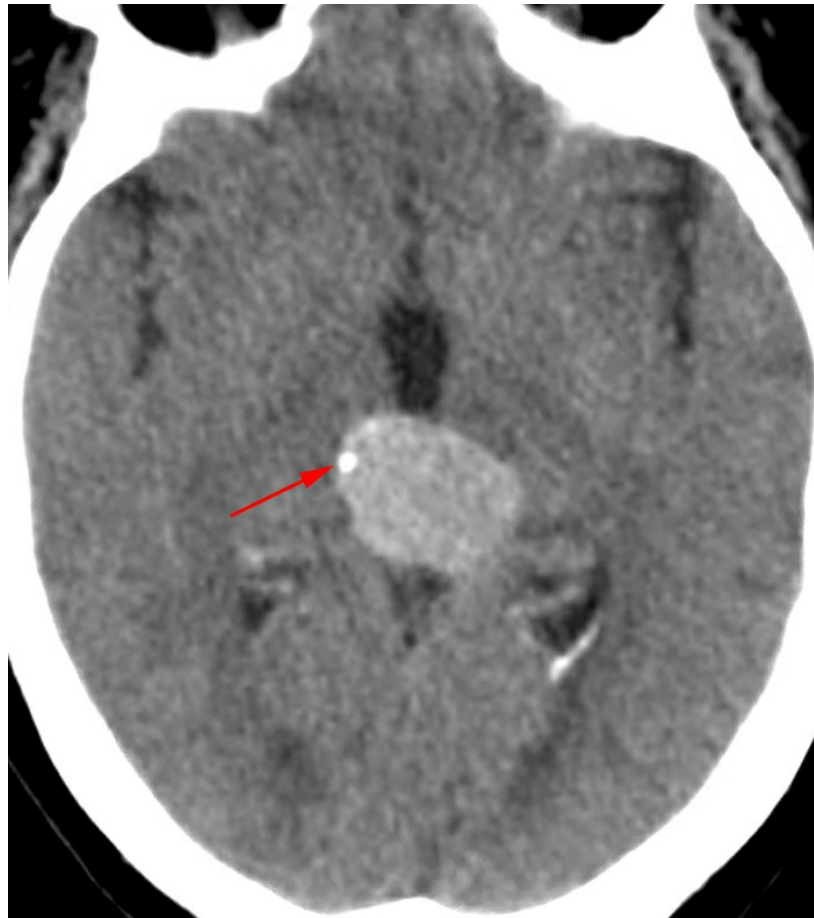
This circumscribed pineocytoma demonstrates peripheral calcifications (arrow) and homogeneous enhancement on postcontrast CT imaging. The lesion is more circumscribed and less infiltrative in appearance than would be more typical for other pineal region tumors.
